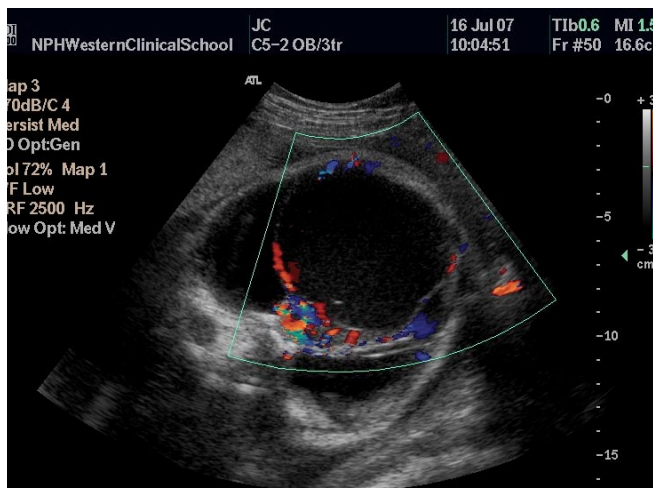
Colour Doppler USS demonstrating no flow within the mass.
